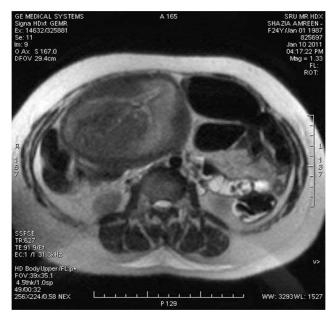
MRI showing placenta increta.
